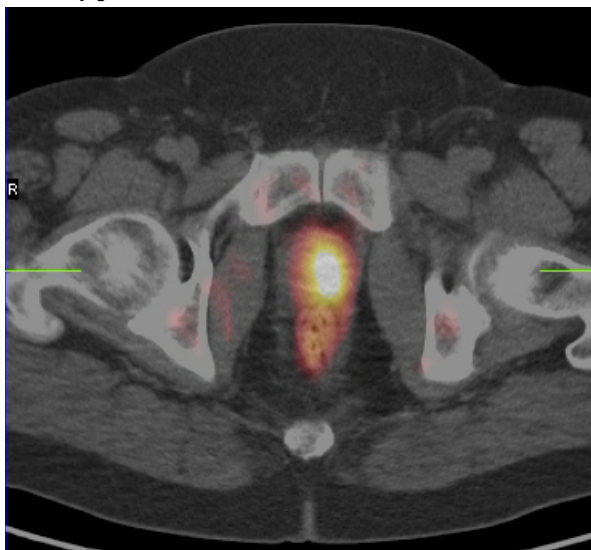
$[^{18}\text{F}]\text{FECh}$ PET/CT for imaging primary prostate cancer: strong uptake in the left lobe.
